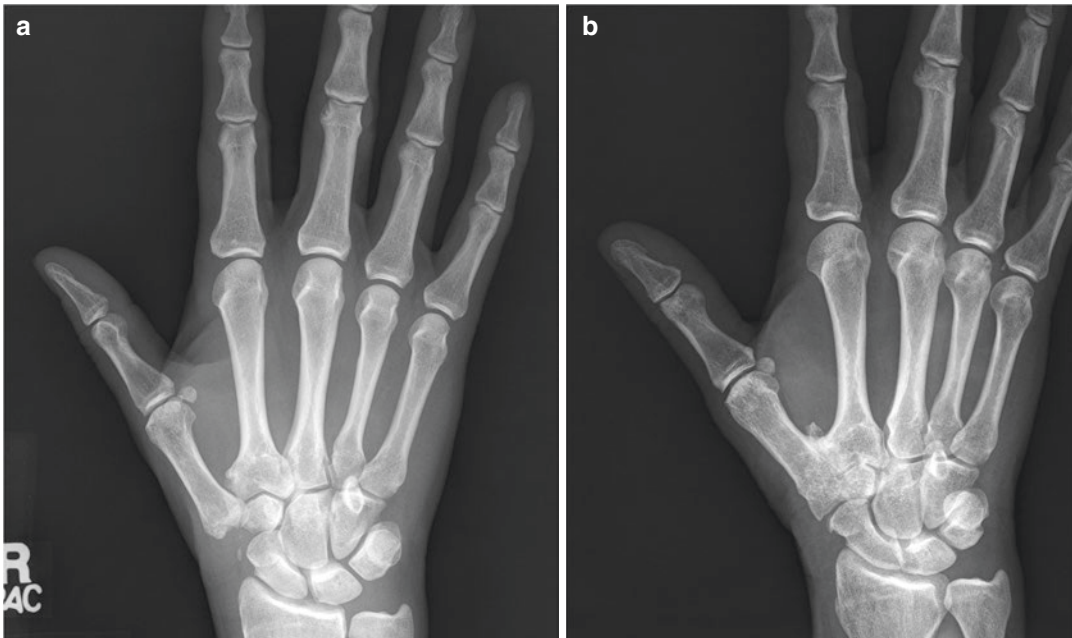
AP radiograph of a 50-year-old laborer with a failed prosthetic arthroplasty which was converted to trapeziectomy (a). Patient complained of ongoing pain and weakness with pinch. To provide stronger pinch, which
